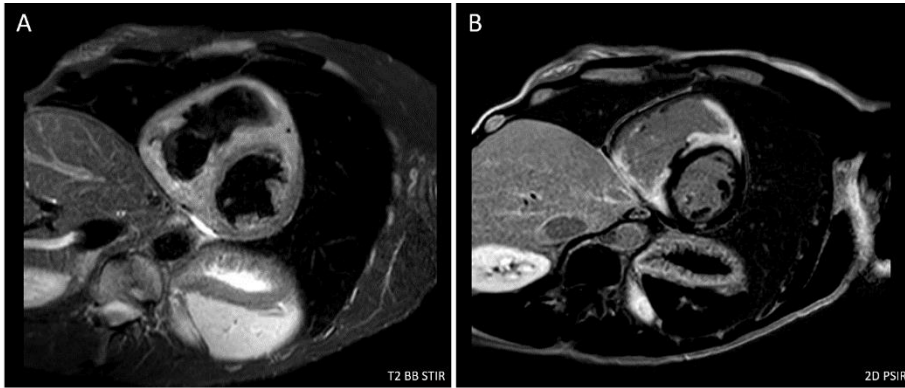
Magnetic resonance imaging scans of a patient diagnosed with giant cell myocarditis showing signs of edema (A), and extensive biventricular late gadolinium enhancement (B).
